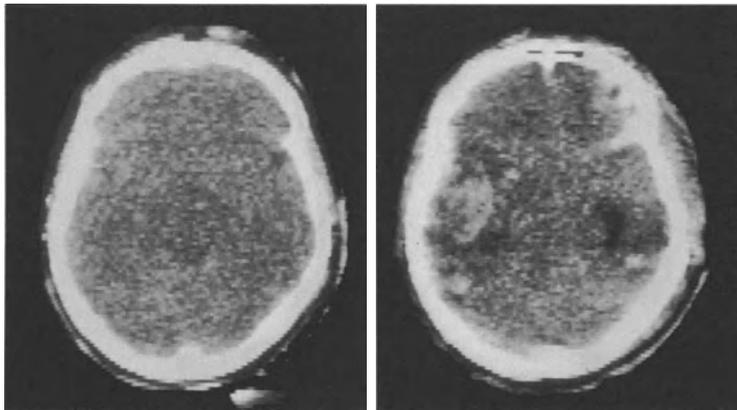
a CT (1 h after the accident) in a 33-year-old man: sign of generalized brain edema with fine left temporal hemorrhagic foci. b CT 24 h later, after clinical deterioration with a large contusion hematoma on the left and signs of temporal herniation with widening of the right temporal horn. After removal of the hematoma, the patient recovered rapidly and survived with an aphasia
